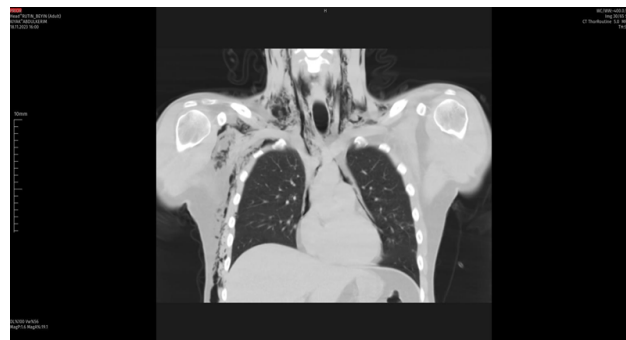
Pneumomediastinum on coronal section of Thorax Computed Tomography
